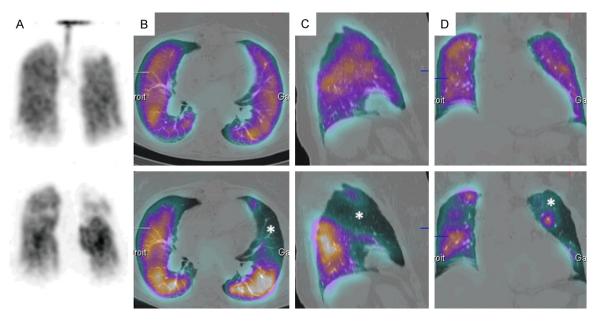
Ventilation/perfusion lung single photon emission computed tomography (V/Q SPECT) showing mismatch. Upper row: ventilation function; Lower row: perfusion function. (A) Planar acquisition; Computed tomography images in axial plane (B), sagittal plane (C) and coronal plane (D), mismatch are indicated with a *.
